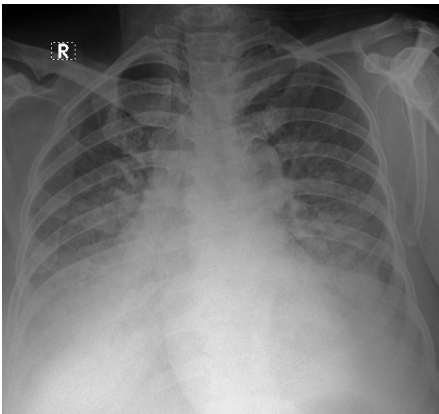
Postpartum Chest X-ray showed moderate pulmonary edema
